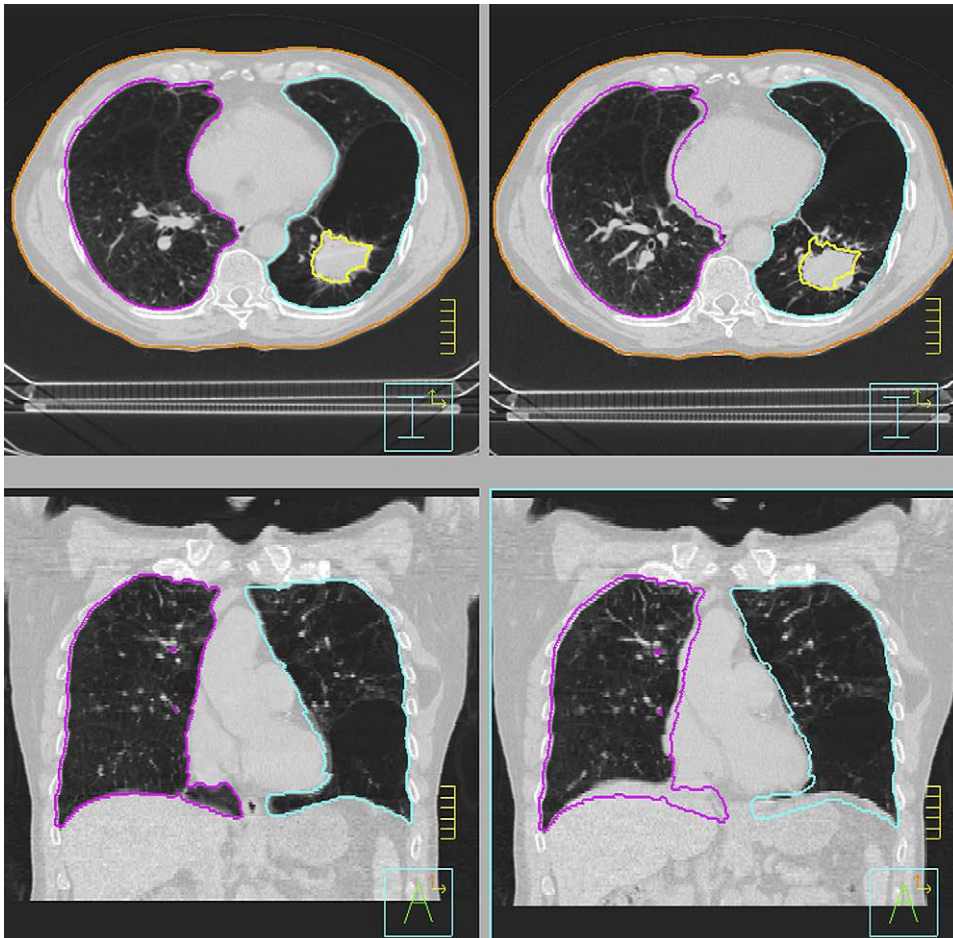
Inhale, 0% phase (left) and exhale, 50% phase (right) reconstructions from the four-dimensional computed tomography images obtained for the example lung patient. The lungs (purple and aqua) and tumor (yellow) are contoured on the inhale image and overlaid onto the exhale image for reference.
